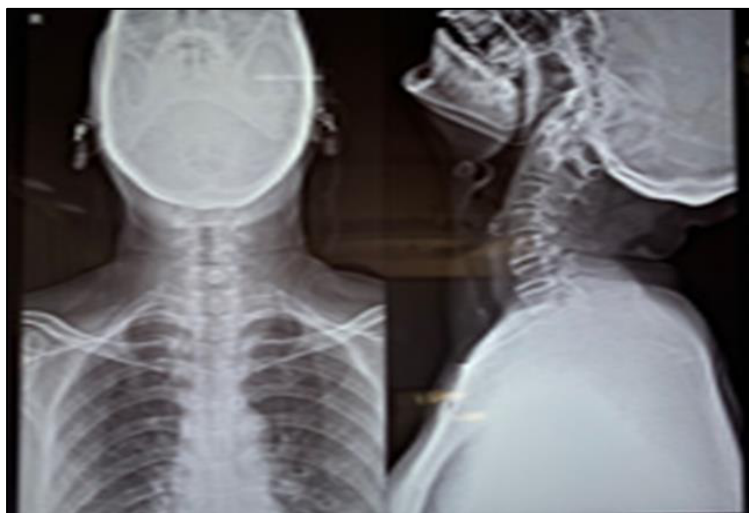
X-ray of the cervical spine (AP & Lateral view)
